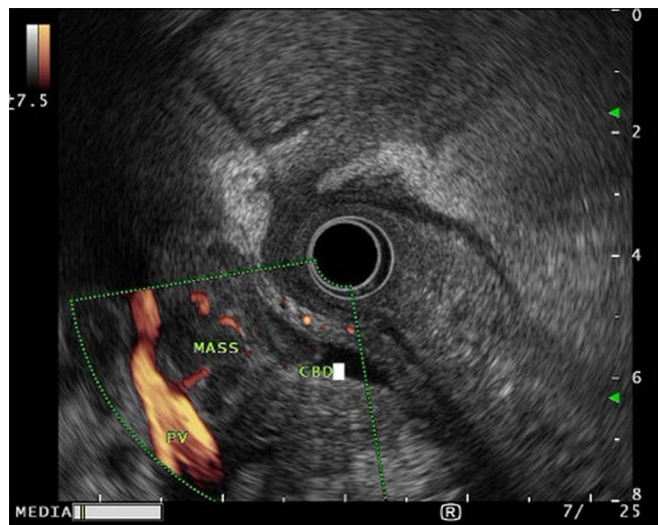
Endoscopic ultrasound showed a pancreatic anaplastic large cell lymphoma invading the portal vein and the mid common bile duct.
